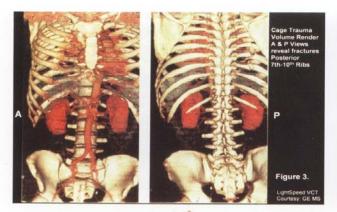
3-D volume rendering of the thoracic cage from multislice CT images. A & P views reveal fractures at posterior 7<sup>th</sup>-10<sup>th</sup> ribs. (LightSpeed VCT Courtesy: GE Medical Systems)
